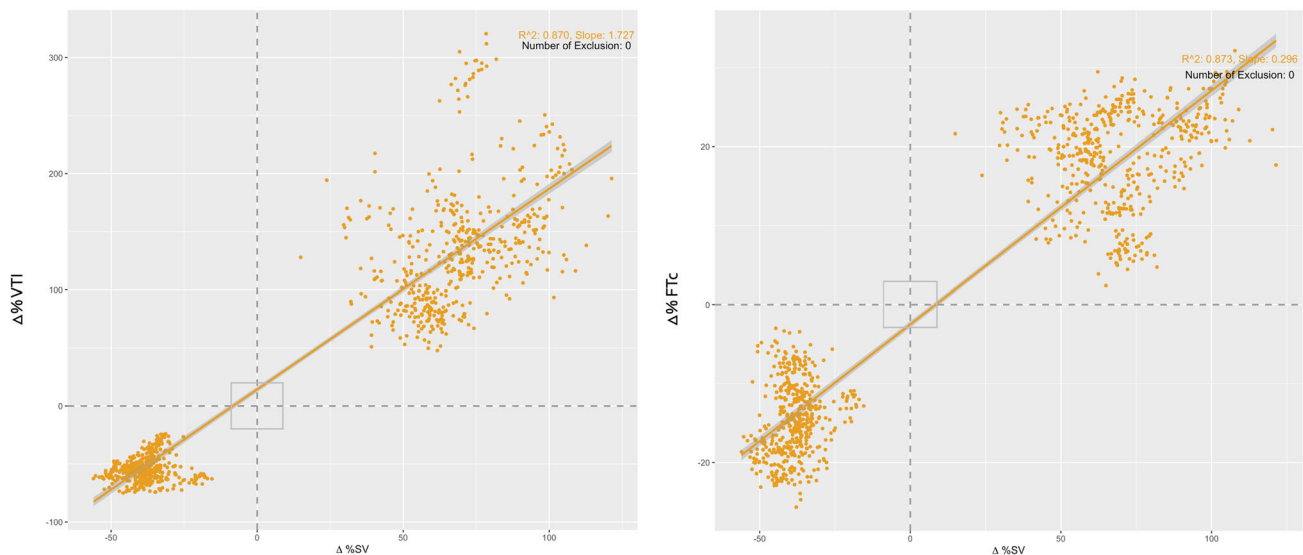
Four quadrant plots for $\Delta\%$ SV versus $\Delta\%$ carotid VTI and FTc. For both measures, no data fell within the zone of exclusion, and there were no discordant beats. Each data point represents a 10-second average of SV and carotid Doppler data. These data are accumulated from 22 lower body negative pressure protocols and 17,822 cardiac cycles. $\Delta\%$, percent change; FTc, corrected flow time; SV, stroke volume; VTI, velocity time integral
